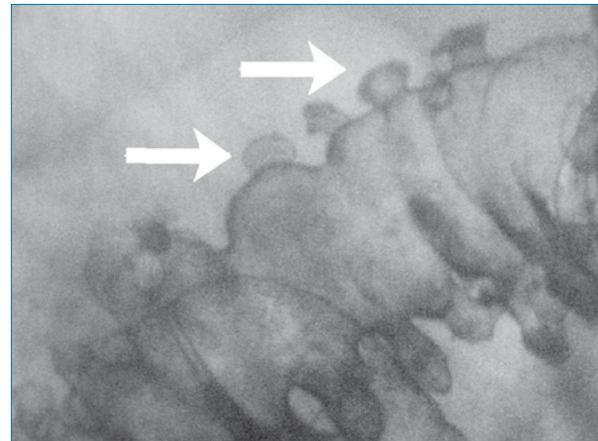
Diverticula in the colon can be visualised on an X-ray by use of a contrast medium.
